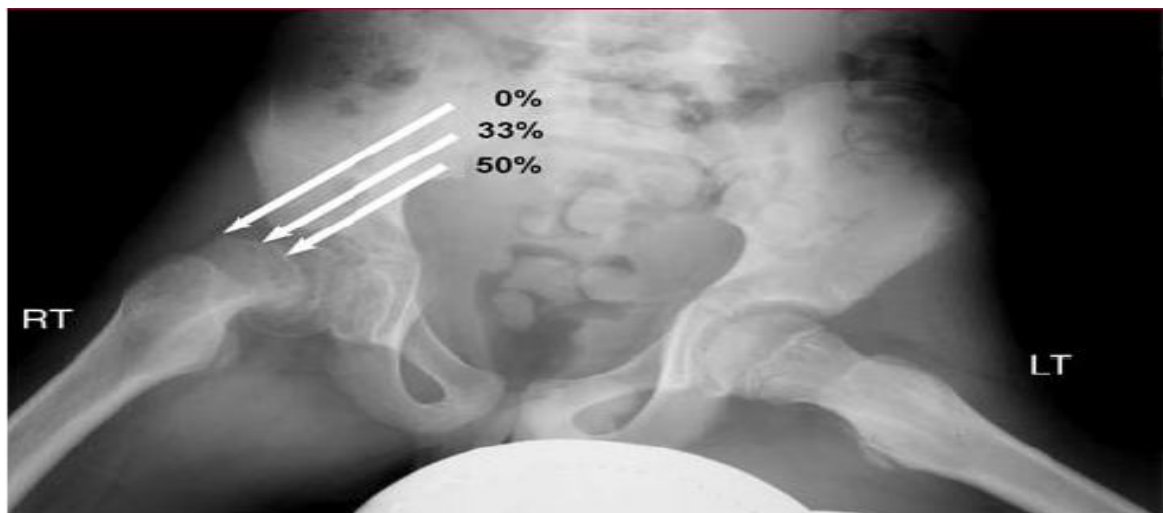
Frog-leg lateral pelvis radiograph showing moderate SCFE of the right hip and a normal left hip. Classification is based on the percentage of displacement of the epiphysis on the width of the metaphysis (mild, < 33%; moderate, 33% to 50%; severe, >50%) (*Aronson et al., 2006*).
